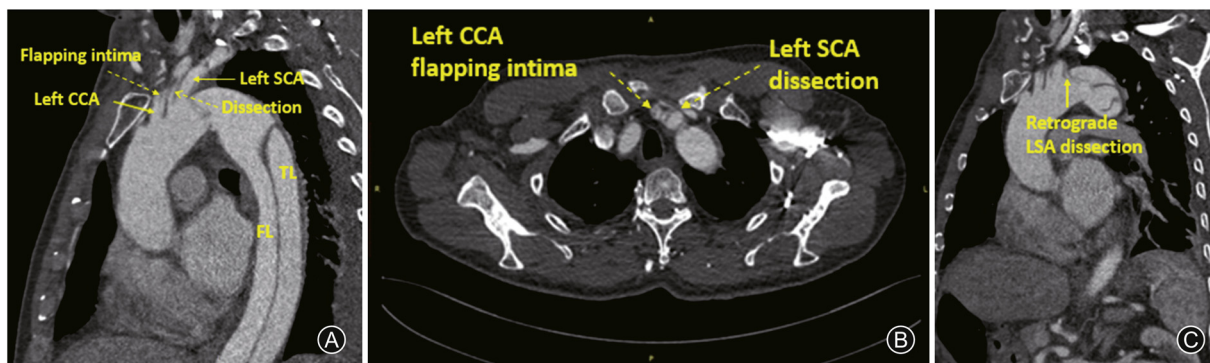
Preoperative computed tomography angiography findings. (A) Imaging in the sagittal plane revealed damage associated with blunt aortic injury at the isthmus, an intimal flap in the LCCA, and dissection of the LSA. (B) The presence of an intimal flap in the LCCA and LSA dissection as viewed in the axial plane. (C) Dissection with LSA involvement as viewed in the sagittal plane. LCCA: left common carotid artery; LSA: left subclavian artery; FL: false lumen; TL: true lumen.
